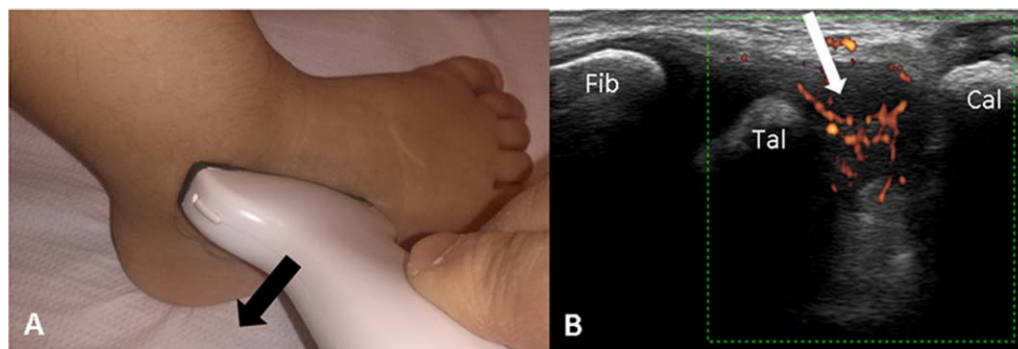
Position of the probe for the lateral scanning approach to the subtalar joint (A) and synovitis (white arrow) (B) exhibiting power Doppler signal through the lateral scanning approach in a 5-year-old girl with juvenile idiopathic arthritis. The black arrow (A) indicates the movement of the probe. Fib = fibula; Tal = talus; Cal = calcaneus.
